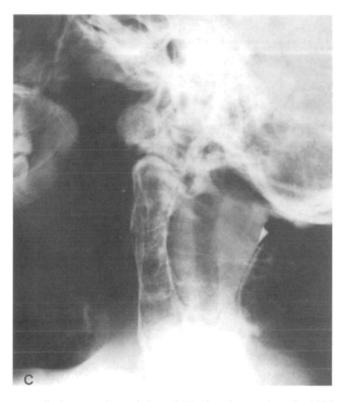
Case 1. (A) Coronal reformatted CT-myelogram showing diastematomyelia between the medulla and C3. Note the anterior spina bifida of C1 and the large odontoid. (B) Axial CT-myelograms demonstrating dysplastic narrow vertebral bodies, with a thin zone of sclerosis in the sagittal plane indicative of an earlier midline defect resulting in separate ossification of right and left halves of each vertebral body and a wide spinal canal. A complete split of the cervical cord is evident in line with the defect of the vertebral bodies. (C) Lateral cervical spine roentgenogram (with intrathecal contrast material) showing extensive fusion between C2 and C7. The large odontoid appears to articulate directly with the short clivus, and there is a posterior assimilation of C1 to occiput.
